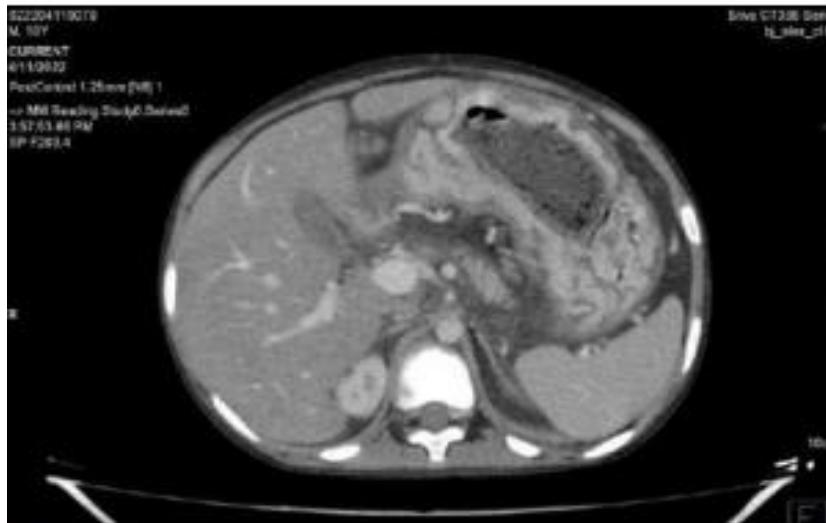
Abdominal computed tomography (CT) images obtained with intravenous Ominpaque showing giant cerebriform enlargement of rugal folds in the gastric fundus and body
